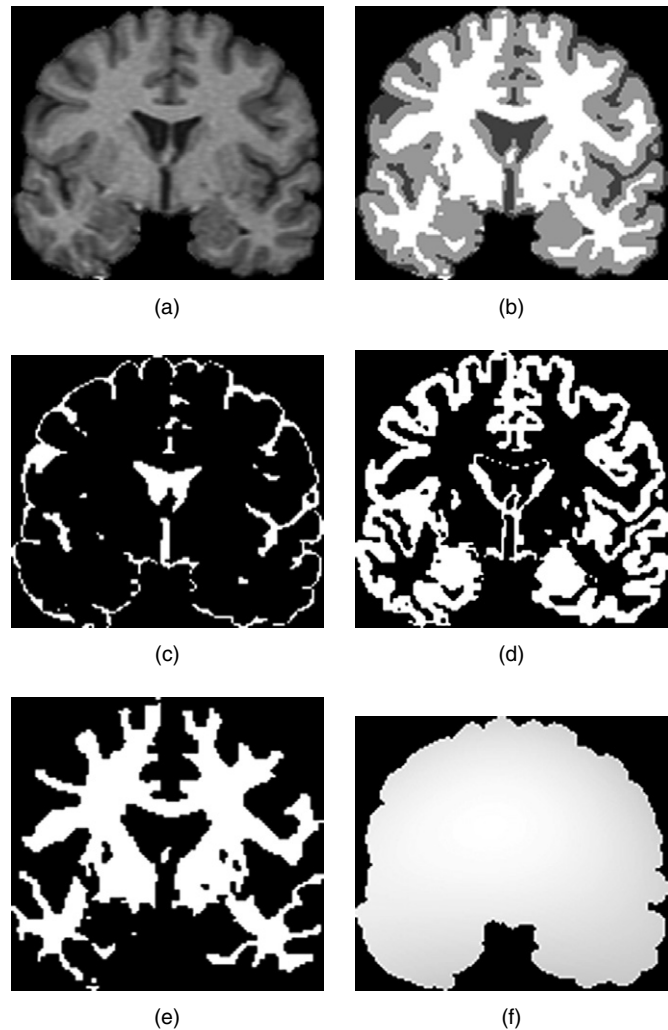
Robust K -means example: (a) T1-weighted MR image, (b) final classification, (c) CSF indicator function, (d) GM indicator function, (e) WM indicator function, (f) estimated inhomogeneity field.
